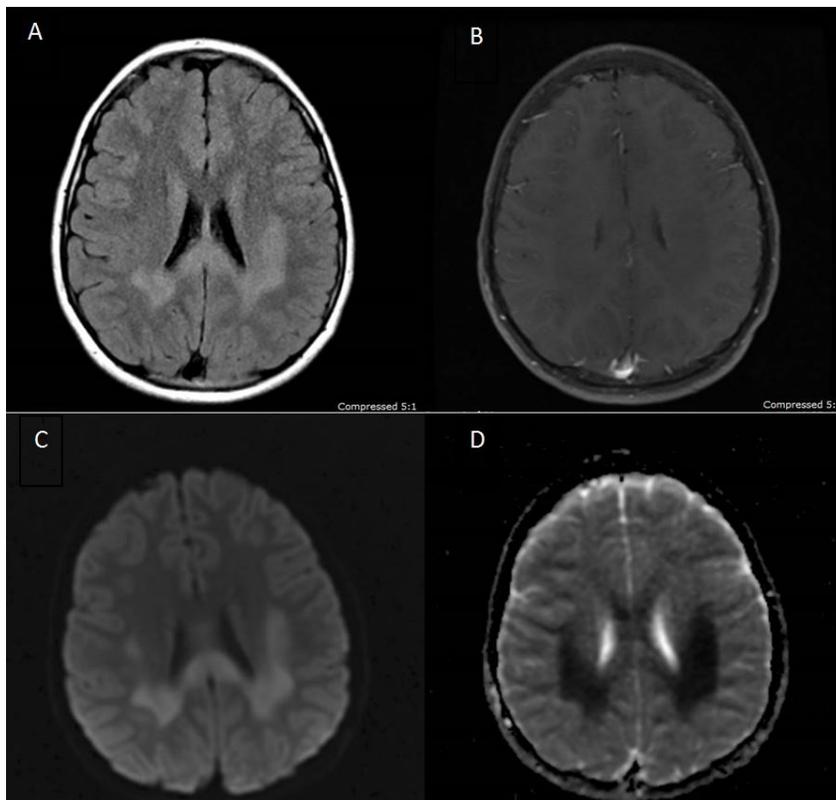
Initial MRI of the brain demonstrates bilateral confluent hyperintense lesions in parietal periventricular white matter and splenium of corpus callosum on axial T2 FLAIR image (A). Post contrast fat suppressed T1 weighted image (B) demonstrates mild hypointensity without enhancement in the lesions. DWI and ADC map (C,D) demonstrate diffusion restriction within the lesions. The findings are suggestive of adrenoleukodystrophy (ALD).
